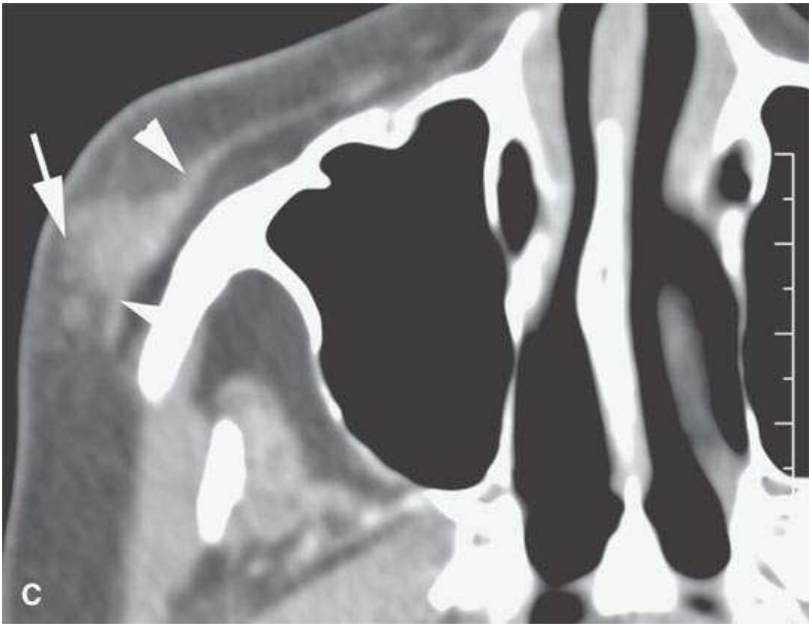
Contrast-enhanced computed tomography of a patient with a Merkel cell carcinoma which is typically a rapidly spreading tumor. A, B: The mass (*arrow*) has a potentially aggressive deep margin (*arrowhead in A*). C: The tumor (*arrow*) tends to remain in the subcutaneous soft tissues and spreads along the superficial aspect of the superficial musculoaponeurotic system, which is thickened (*arrowheads*).
